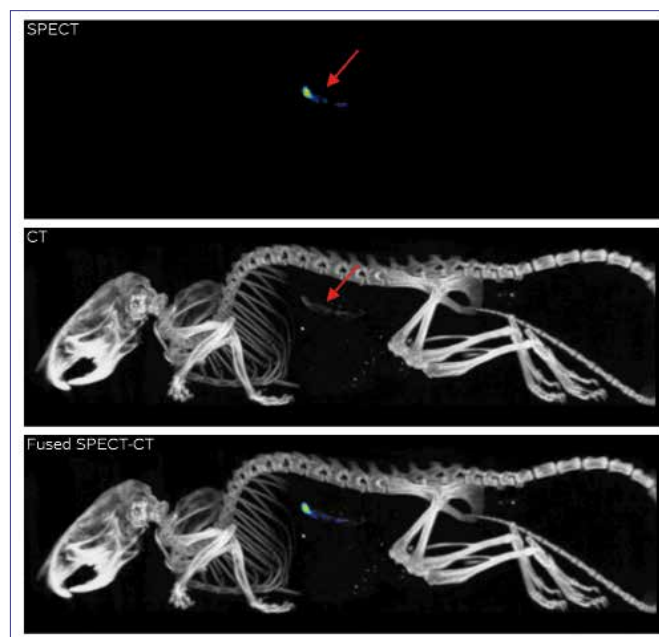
Example of SPECT/CT imaging: holmium-166 acetate microspheres ( $^{166}\text{HoAcAcMS}$ ) are used for treatment of kidney tumours (for details see reference 20).  $^{166}\text{Ho}$  emits high-energy beta particles suitable for anticancer therapy and the simultaneously emitted gamma rays (81 keV) allow for SPECT imaging. Moreover, nonradioactive holmium-165 can be visualised by CT. Arrows indicate the presence of the microspheres in the kidney area in the SPECT and CT images. The fused SPECT/CT image clearly shows agreement between the SPECT and CT signals. Images courtesy of W. Bult, University Medical Centre Utrecht, the Netherlands.
